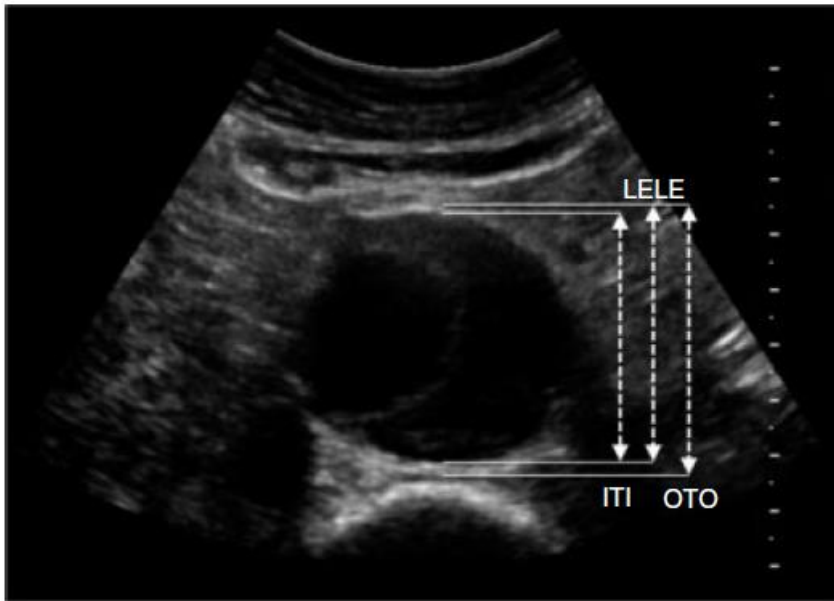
Ultrasound methods to measure the diameter of the abdominal aorta: outer-to-outer (OTO) method, inner-to-inner (ITI) method and leading edge-to-leading edge (LELE) method
